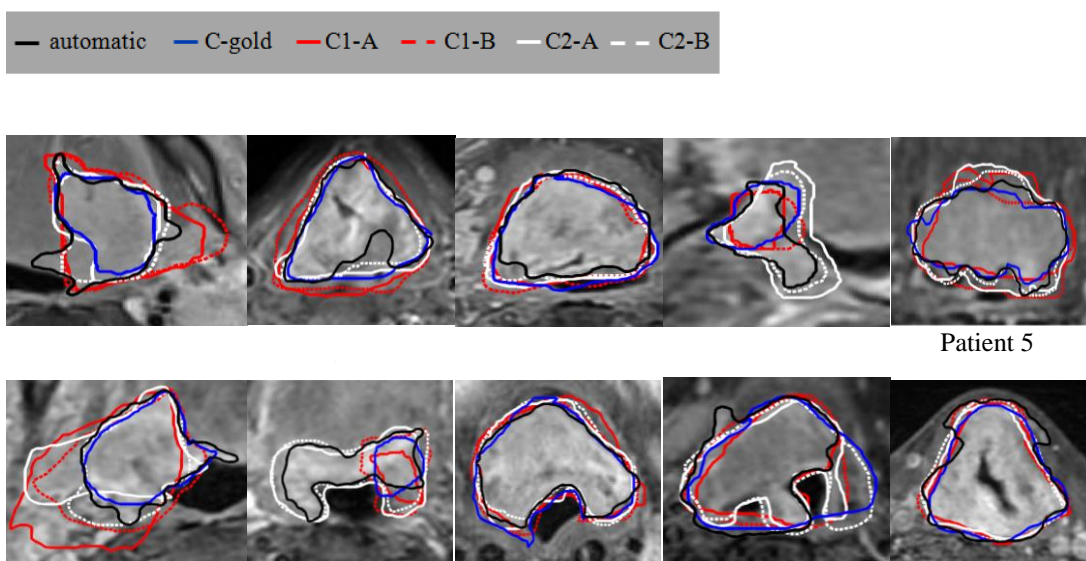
10 axial MRI slices from 10 different patients comparing C-auto with manual (C-gold, C1-A, C2-A, C1-B and C2-B) tumour outlines
